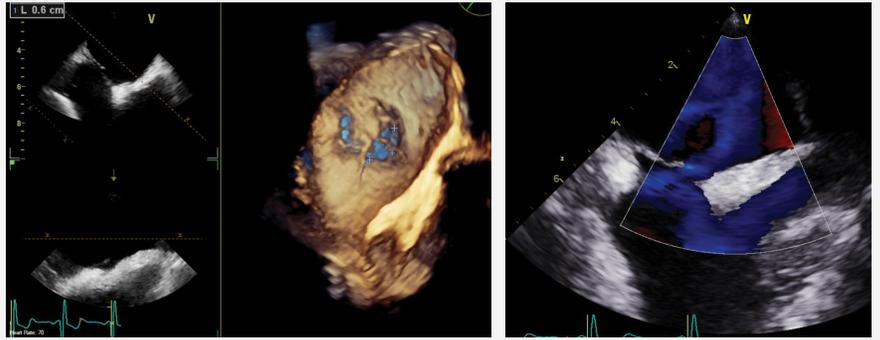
A) Transesophageal echocardiogram showing a 3D reconstruction of a large patent foramen ovale.
